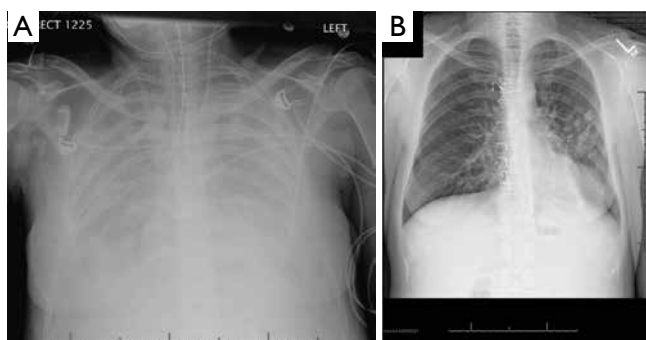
(A) Preoperative Chest X-ray; (B) Postoperative Chest X-ray.
